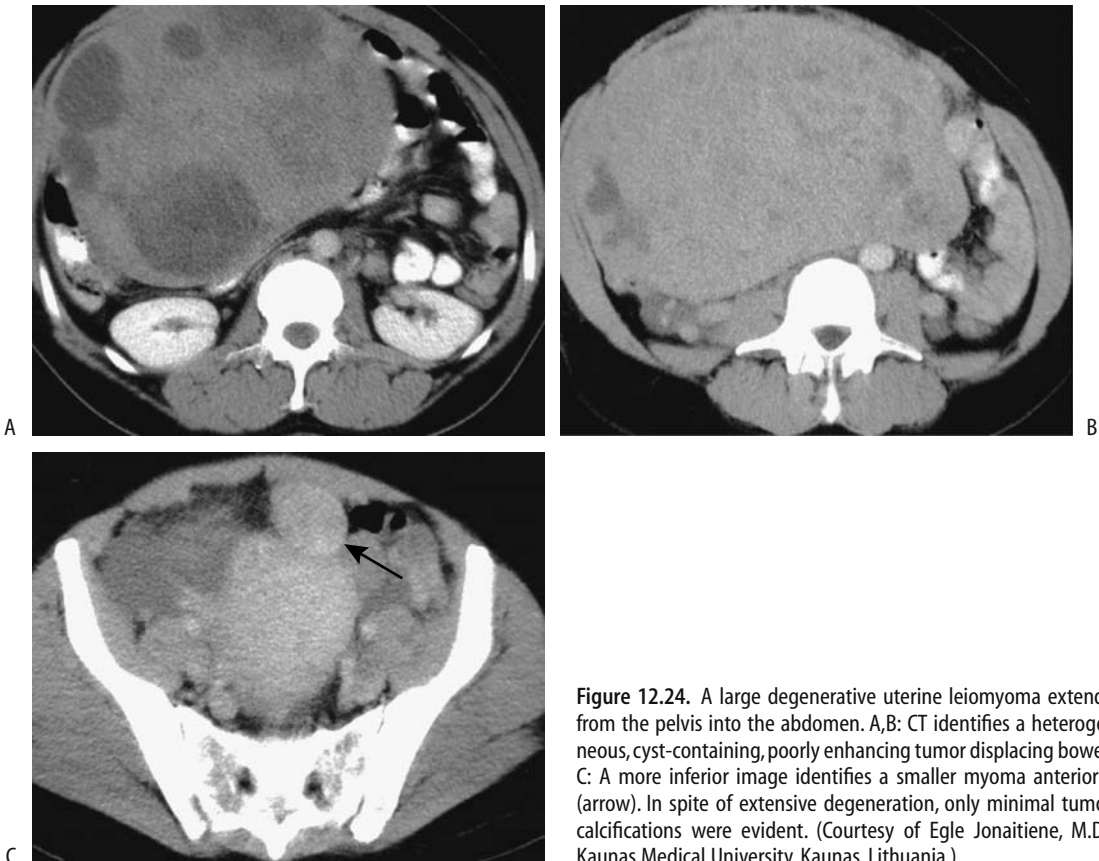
A large degenerative uterine leiomyoma extends from the pelvis into the abdomen. A,B: CT identifies a heterogeneous, cyst-containing, poorly enhancing tumor displacing bowel. C: A more inferior image identifies a smaller myoma anteriorly (arrow). In spite of extensive degeneration, only minimal tumor calcifications were evident. (Courtesy of Egle Jonaitiene, M.D., Kaunas Medical University, Kaunas, Lithuania.)
